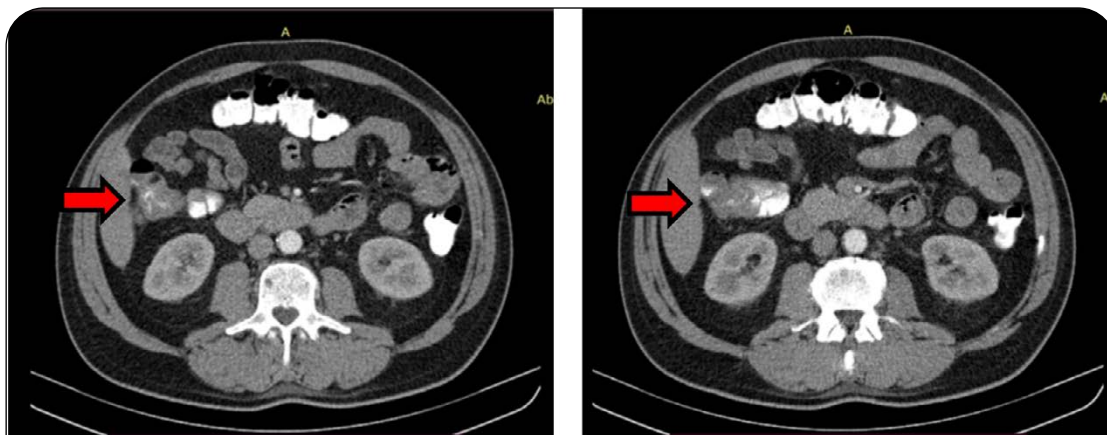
Double abdomen and pelvis contrast CT scan. Focal, asymmetric bowel wall thickening is observed, which compromises the ascending colon.
